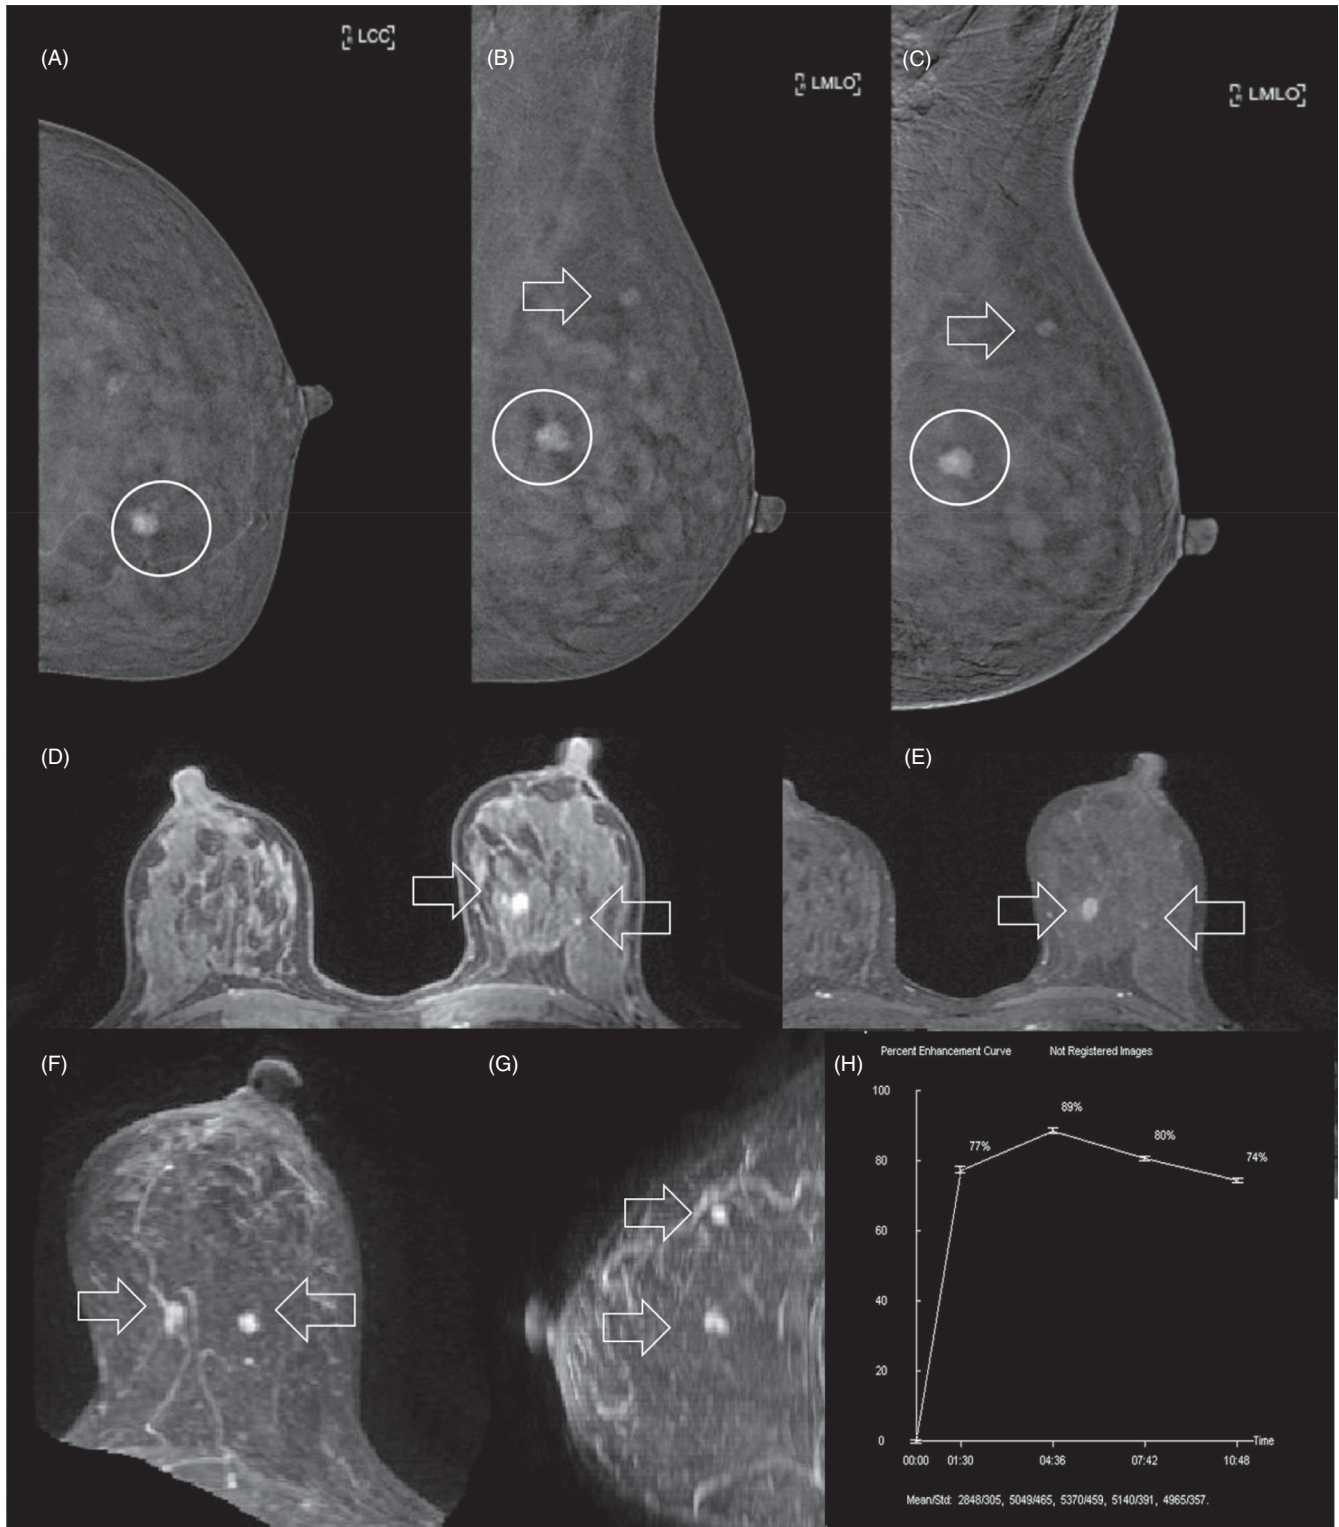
The same patient of Figures 9 and 10. Left breast CEDM. Cranio-caudal (A) and oblique (B, C) images. Two small enhancing tumor foci are visible. Left breast DCE-MRI. Two intensely enhancing tumor foci are visible (D-G). Quick wash-in TICs with persistent enhancement (H)
